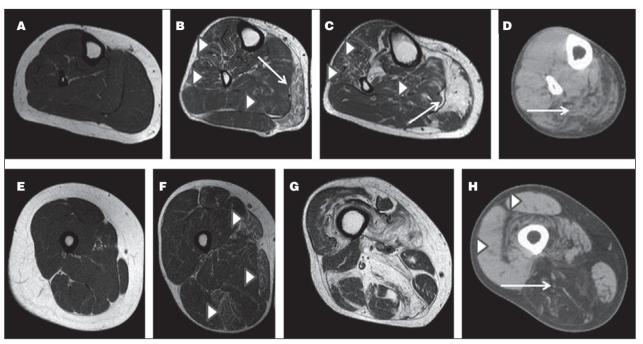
Normal leg (A) and thigh (E) muscle MRI in a patient affected by PMC. Marked T1w changes in medial gastrocnemius (arrows) in a patient with recessive MC (B) and in a patient with HypoPP type I (C) in association with lower severity involvement of soleus, peroneal longus and tibial anterior (arrowheads). Both patients had also thigh involvement, limited to sartorius, gracilis and semitendinosus (arrowheads) in recessive MC (F), more marked and diffuse in HypoPP type I (G). Muscle CT scan hypodensity (arrows) limited to posterior leg (D) and predominant in posterior thigh (H) in a patient with HyperPP. To be noticed the sparing of rectus and vastus lateralis (arrowheads).
